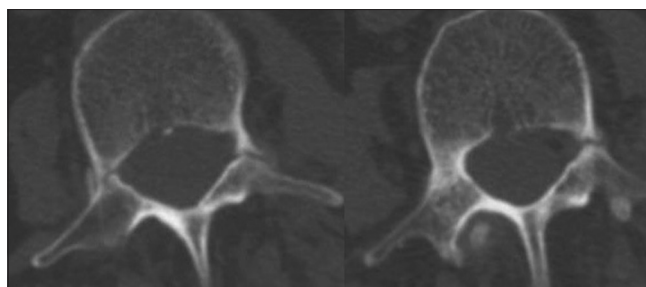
Axial computed tomography of L2 (left) and L3 (right) demonstrating complete left L2 and L3 pedicle fractures, right L2 incomplete pedicle fracture, and sclerosis of right L3 pedicle
